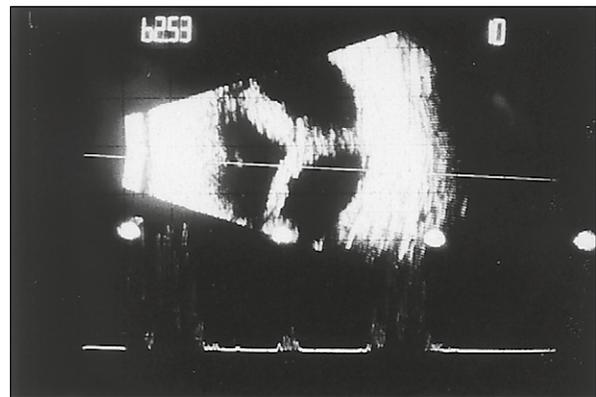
Ultrasonogram of a patient with a large 'kissing choroida' with filtering surgery that is overfunctioning.
